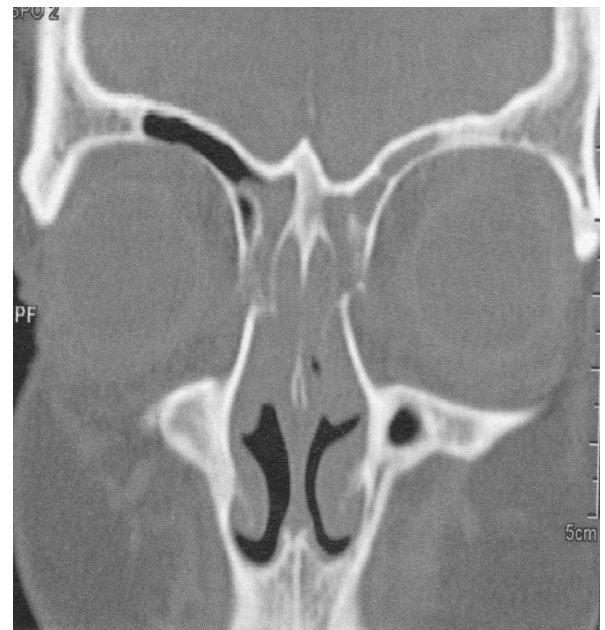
CT image. Native examination
